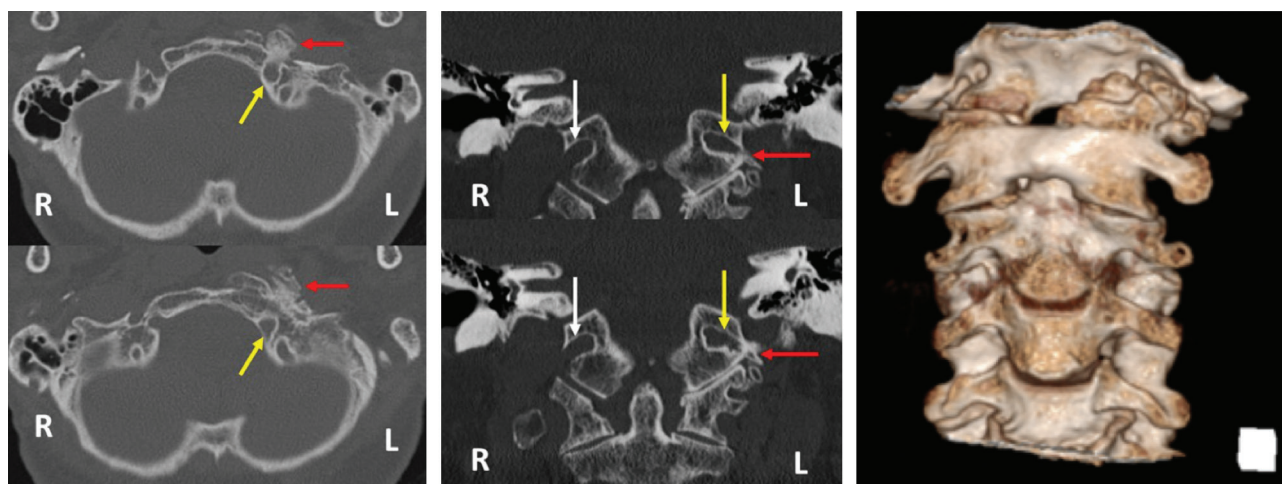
Axial bone CT (left panel) shows the osteophyte (red arrow) facing the external orifice of the left hypoglossal canal (yellow arrow). Coronal bone CT at the hypoglossal canal (mid panel) shows that the right hypoglossal canal (white arrow) was widely open, while the external orifice of the left hypoglossal canal (yellow arrow) was obstructed by the osteophyte (red arrow). 3D-CT shows the large osteophyte on the external orifice of left hypoglossal canal (right panel). 3D-CT: three-dimensional computed tomography.
